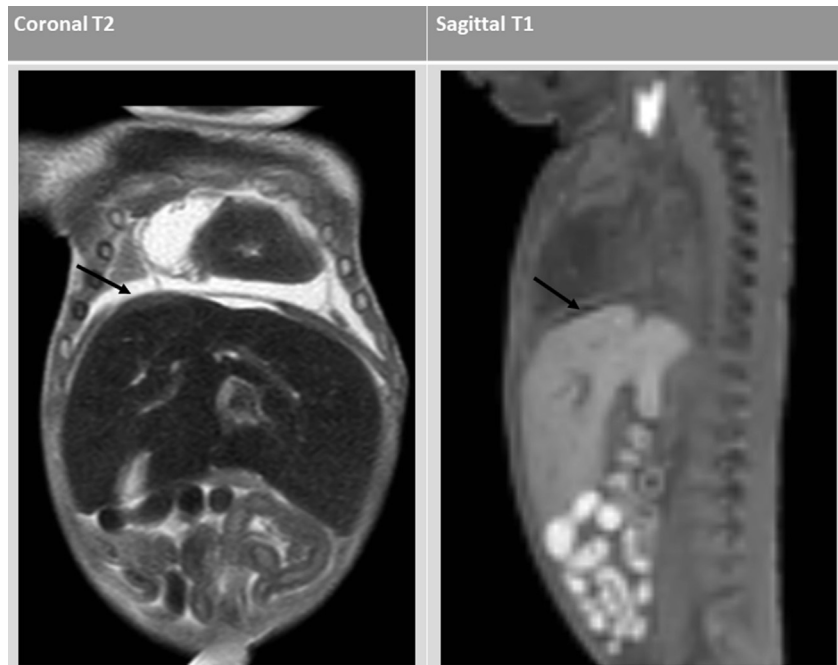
Example of missed subcapsular haematoma on PMMRI (discordant with autopsy, where the subcapsular haematoma is seen). Retrospectively, a small subcapsular haematoma is identified (black arrows), likely initially missed due to signal intensity on T2-weighted images similar to the intensity of normal liver parenchyma.
